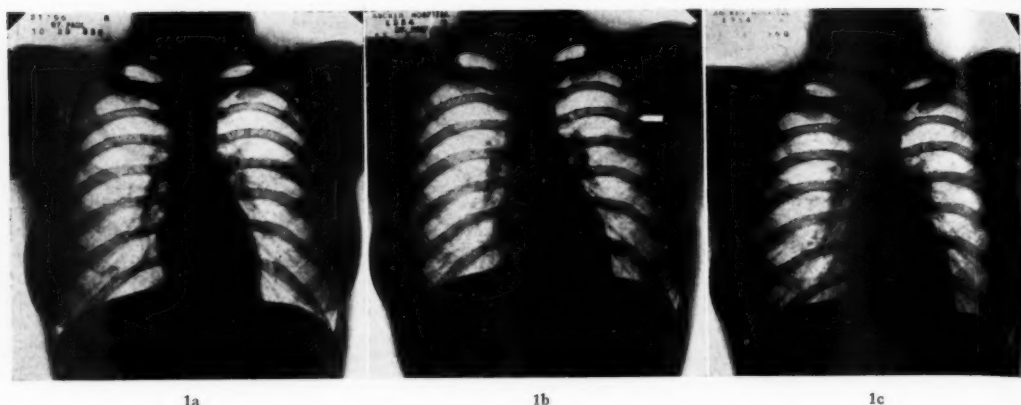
Case 1. *a*, October, 1933—Chest radiograph shows no abnormalities. *b*, November, 1934—Parenchymal lesion in left second interspace. *c*, January, 1936—Complete resolution of left upper lesion without treatment.
